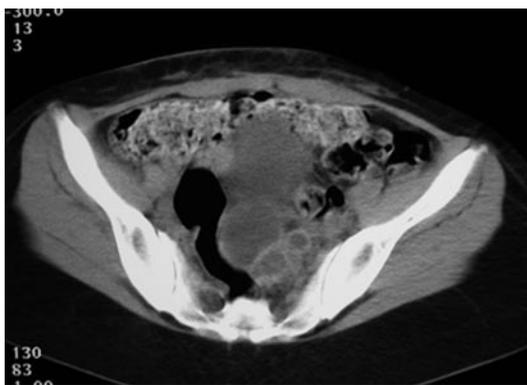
CT image of a large retroperitoneal echinococcal cyst in contact with the left ovary and left ureter.
